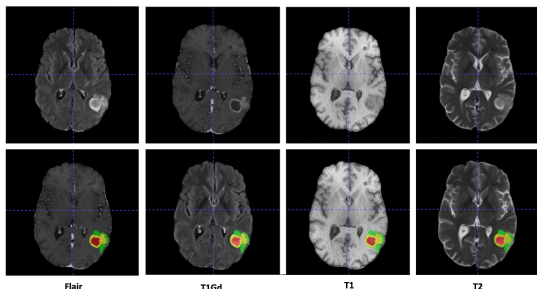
Example of MRI Brain Tumor Image
